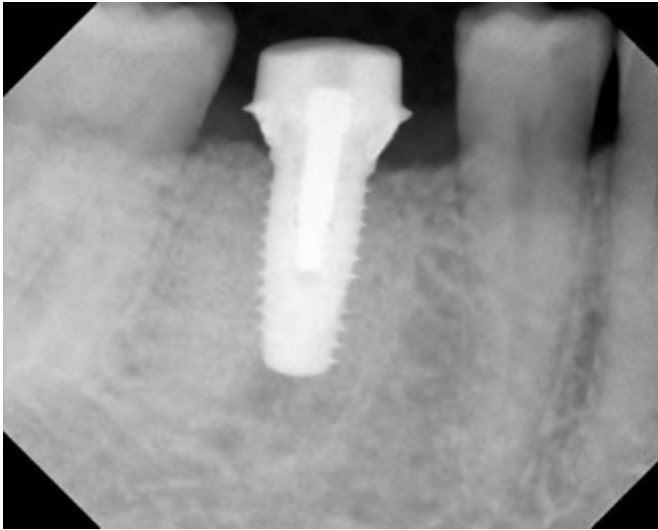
Periapical radiograph with the definitive abutment in place demonstrated that the abutment was seated properly onto the implant restorative platform. An ill-fitting abutment would be identified by a radiolucent space between the abutment and implant restorative platform.
